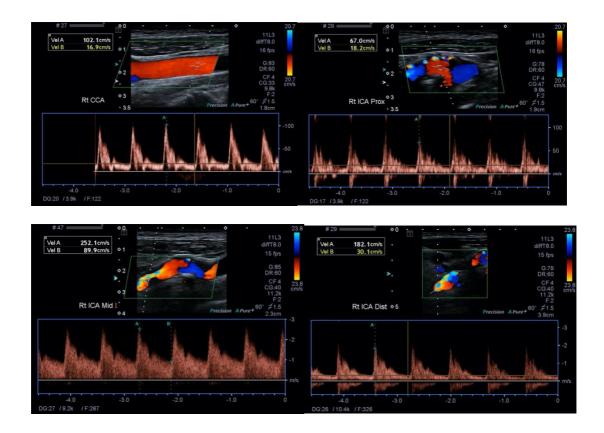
Selected US images demonstrated normal CCA (top left), normal proximal ICA (top right), a stenosis in the mid right ICA (bottom left), and elevated velocities in the distal right ICA (bottom right). Colour aliasing in the image on the bottom right image highlights the likely area of maximal velocity increase to which the PW Doppler sample-box is placed with an angle parallel to the vessel walls (direction of flow) and <60 degrees relative to the PW beam.
